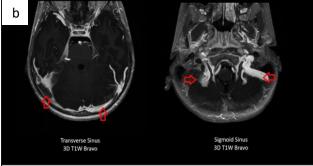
(a and b): MRI brain (plain and contrast) of the patient demonstrating loss of flow void and distension of the superior sagittal, right transverse, and right sigmoid sinuses. T1 hyperintense, T2 isointense signals with blooming on gradient images and post-contrast filling defects are suggestive of cortical venous sinus thrombosis.
